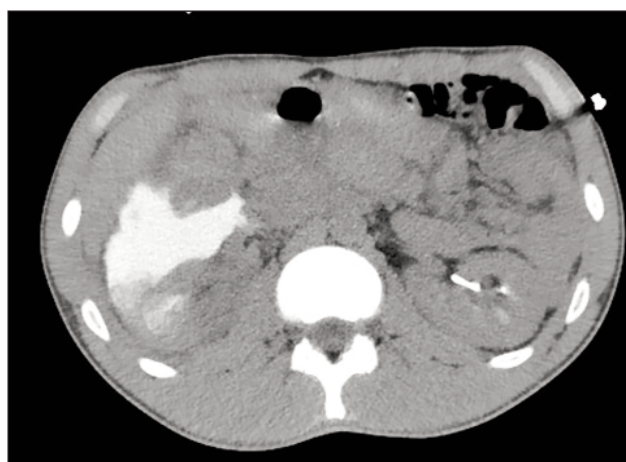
Contrast-enhanced CT at urographic phase showing right kidney laceration and large amount of contrast extravasation in the retroperitoneal space corresponding to urinoma
